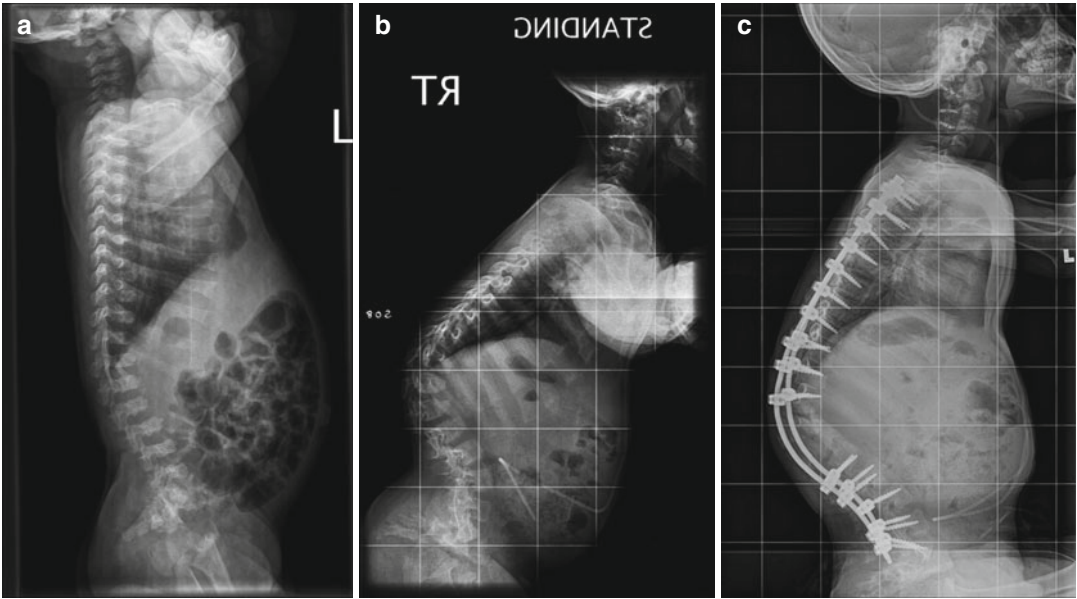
Lateral radiographs of a patient with achondroplasia (a) 10 weeks of age with typical anterior vertebral body dysplasia at the thoracolumbar junction; (b) 5 years of age with progressive thoracolumbar kyphosis and sagittal imbalance; (c) 7 years of age and 2 years postoperative anterior spinal fusion with rib strut graft and posterior spinal fusion and instrumentation with apical Ponte osteotomies
